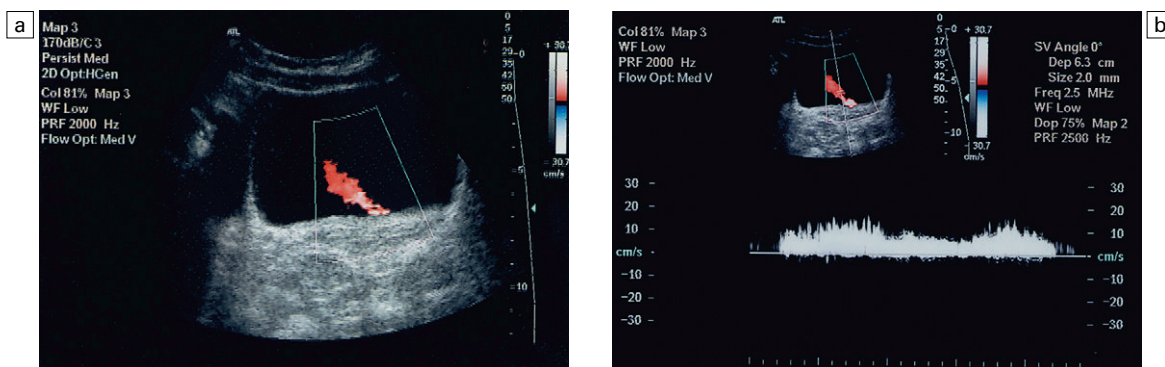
(a) Colour flow Doppler of left ureteric jet. (b) Spectral Doppler of the burst of urine into the bladder.
